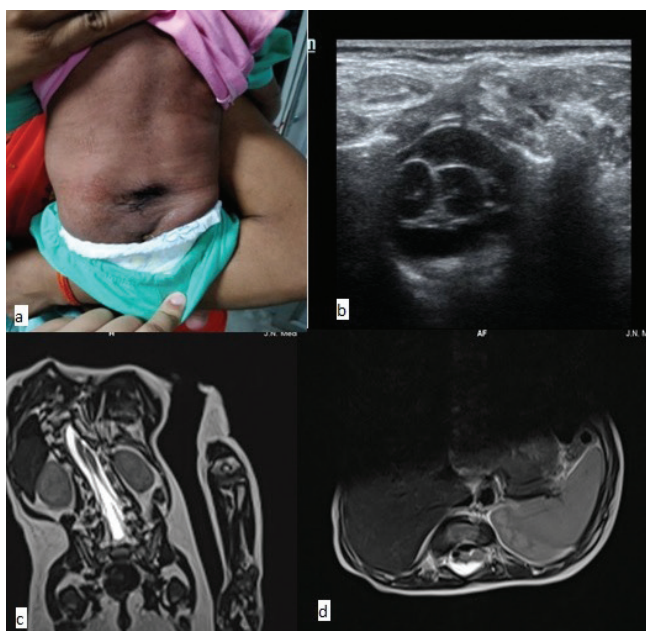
(a,b): High resolution ultrasound image of the patient of closed spinal tube defect with splitting of lower spinal cord into two hemi-cords within a single dural sac with no fibrous/bony bar - type 2 diastematomyelia. (c,d): Coronal and axial T2 weighted MRI spine shows splitting of the terminal part of spinal cord into two hemi-cords without any intervening septa s/o type 2 diastematomyelia
